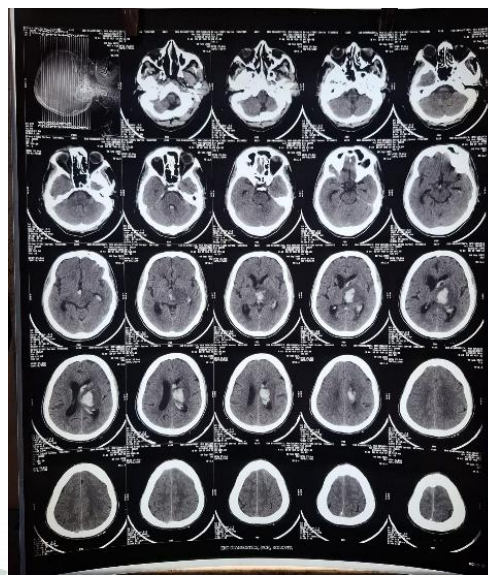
CT Scan of brain showing haemorrhagic CVA
